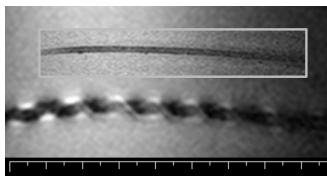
Antiparallel cylindrical coils with no (small box) and 25 mA DC in a water bath at T2-weighted turbo-spinecho imaging (TR/TE = 2000ms/80 ms).
